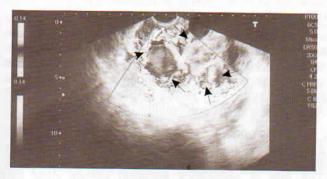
Enhancement of cystic spaces with colour Doppler
